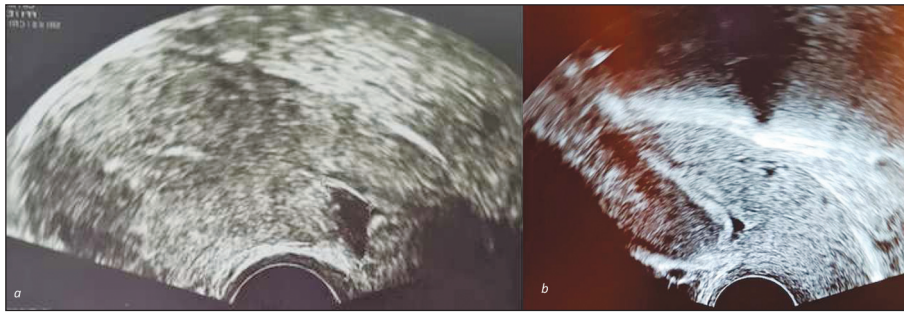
Imaging of isthmocele contours before (a) and following saline infusion sonography(b)
